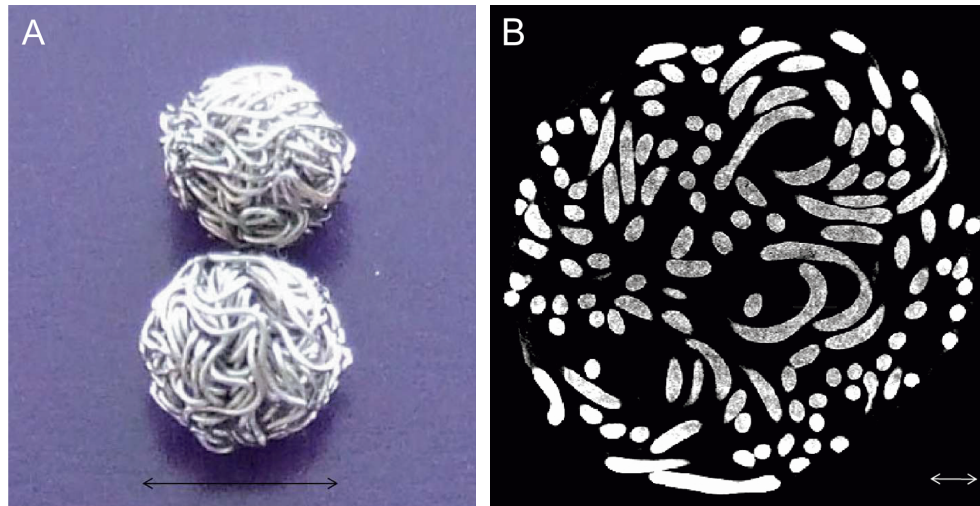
Photograph and X-ray computerized tomography of a titanium wire ball (TWB). (A) TWBs were processed into 4-mm-diameter balls with 83% internal void ratio. (B) Both ends were buried into the central portion to avoid self-relaxing. The 83% internal void ratio created 300–500 μm gaps in the TWBs. Black arrow, 4 mm; white arrow, 400 μm.
